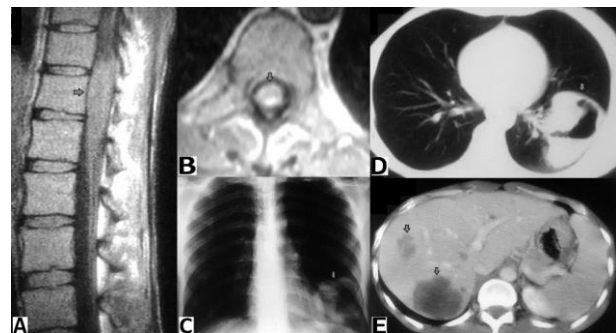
Images of patient 2; (arrows: the tumour in different locations). (A): sagittal T1 WI spinal MRI, showing the conus medullaris tumour; (B): axial T1 WI spinal MRI; (C): chest X-rays
